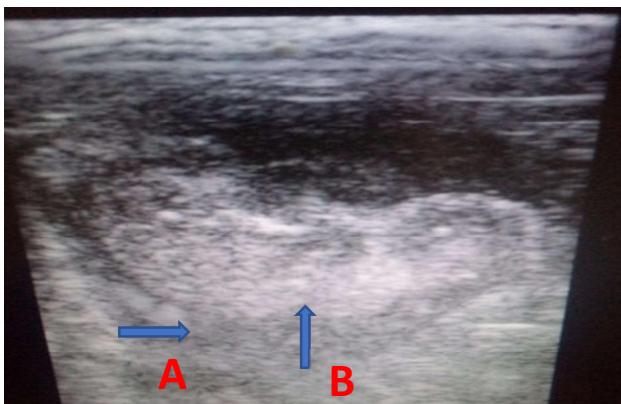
sonogram showing anechoic fluid (A) and longitudinal section of non-motile fetus in-utero (B)
